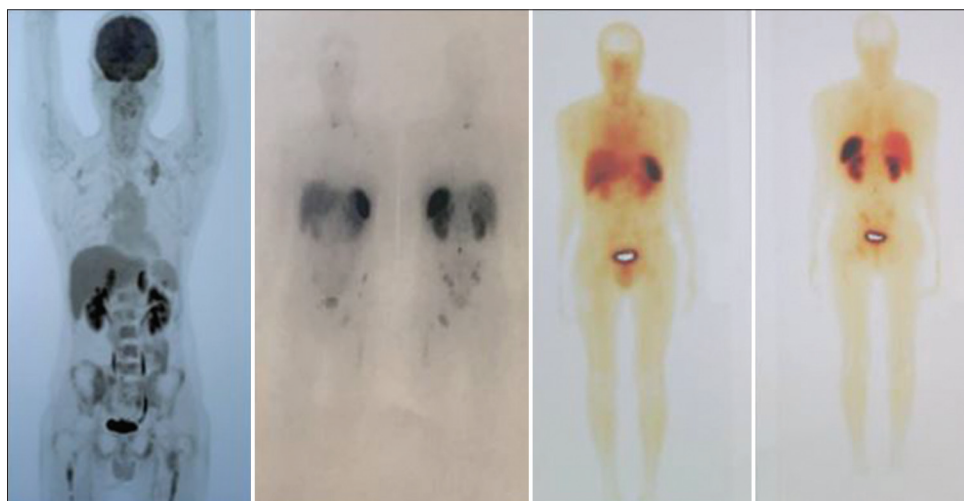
A 29-year-old man with poorly differentiated neuroendocrine tumor (Ki-67 = 28%). ^{99m}Tc-octreotide scintigraphy and post-¹⁷⁷Lu-DOTATATE therapy images showed intense uptake within the skeletal lesions, predicting a good response to ¹⁷⁷Lu-DOTATATE therapy in patients with somatostatin-expressing neuroendocrine tumors. However, ¹⁸F-fluorodeoxyglucose positron emission tomography-computed tomography images demonstrated numerous ¹⁸F-fluorodeoxyglucose-avid lesions throughout the skeleton and marrow, representing a poor prognosis
